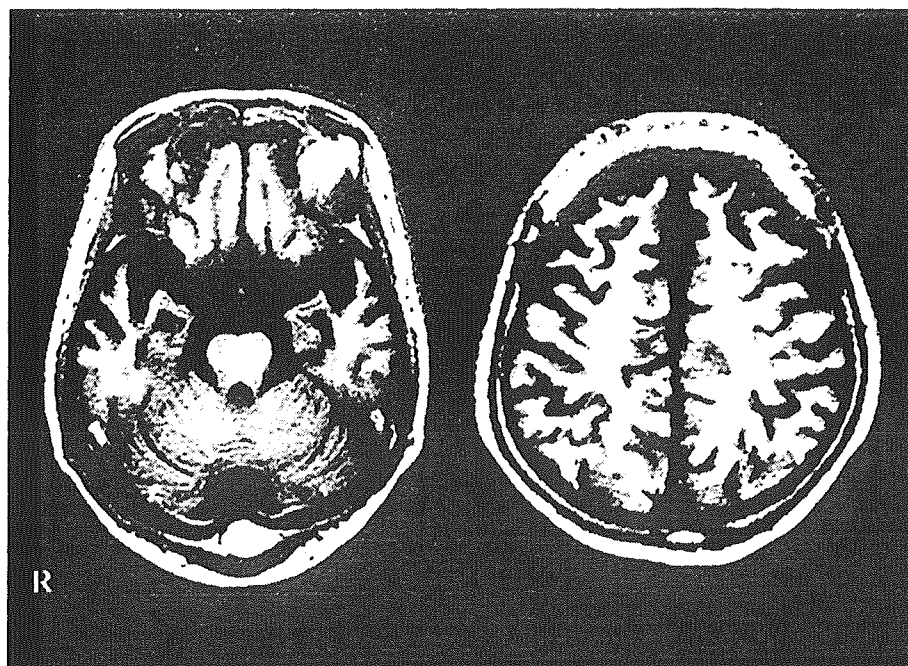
MRI performed 6 months after the initial visit. Symmetrical atrophy of the both anterior temporal and frontal lobes can be seen.
